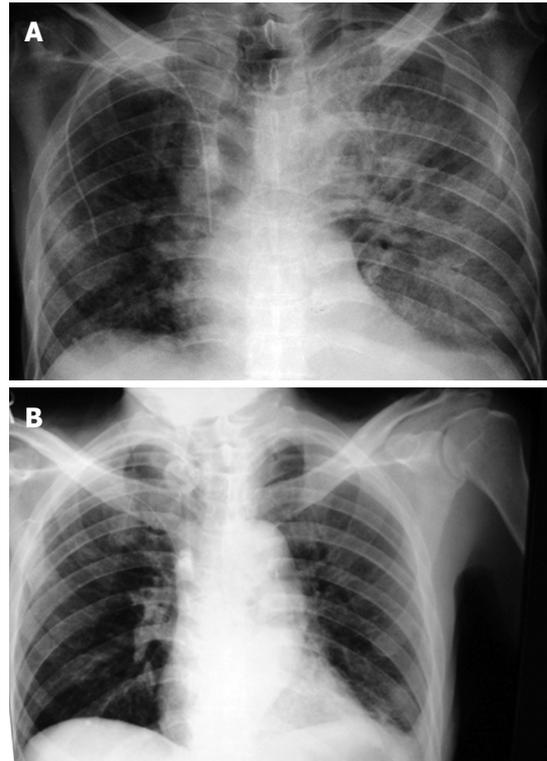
Chest X-ray. A: Chest X-ray taken at time of admission showing Acute respiratory distress syndrome (ARDS); B: Chest X-ray after surgical colectomy showing a significant improvement of ARDS.
